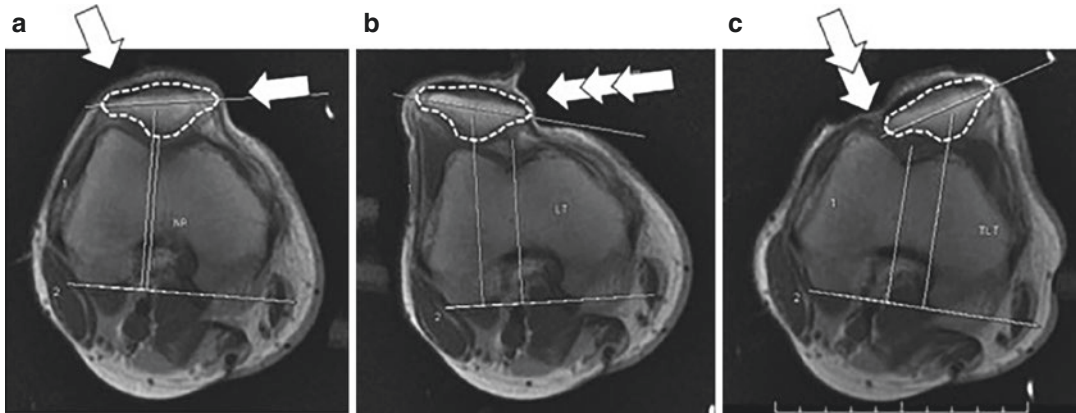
MR images of the patellofemoral joint stress testing through instrumented assessment: (a) patellar neutral position without loading; (b) patellar lateral translation under loading; (c) patellar external tilt under loading, in axial view
